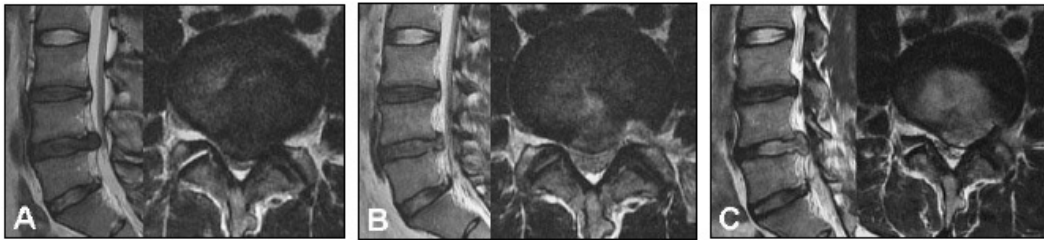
Recurrence after PELD. Recurrence after PELD may be related to the early segmental loading to the operation segment after percutaneous endoscopic lumbar discectomy. (A) Preoperative MRI, (B) Immediate postoperative MRI, (C) Recurrence 3 months after PELD.
